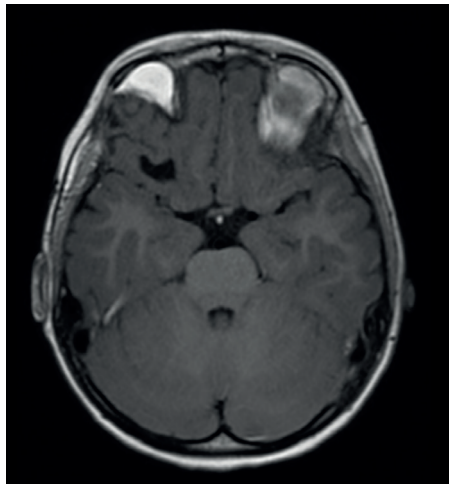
The second-year followed up of T1-weighted contrast of MRI of the brain (axial)
